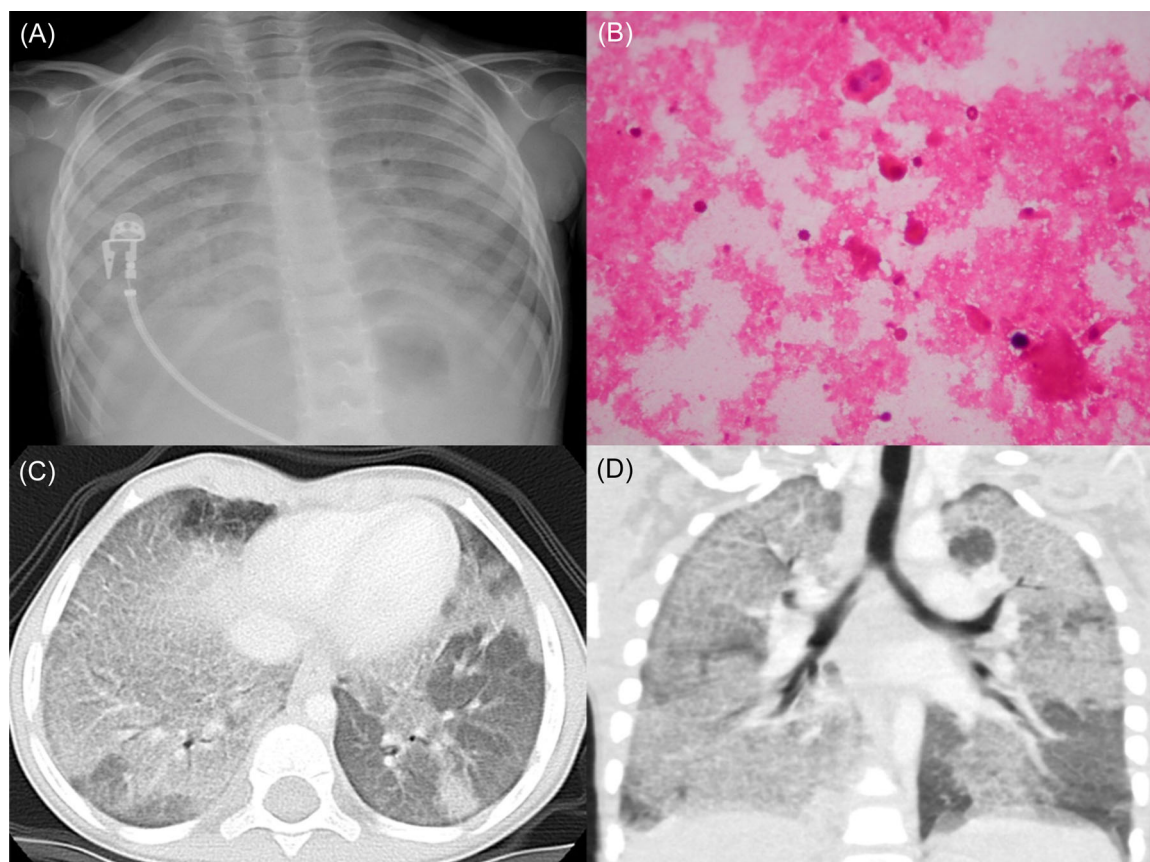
(A) PA chest X-ray demonstrates bilateral diffuse ground-glass opacities. (B) Amorphous eosinophilic hyaline material with macrophages in bronchoalveolar lavage fluid. (C) CT at the level of the lower lobes shows crazy-paving pattern, combining smooth interlobular septal thickening and ground-glass opacities. (D) Coronal reformatted CT image shows that the right lung has diffuse pattern of disease, whereas the left lung has somewhat geographic pattern with spared areas of upper and lower lobes. CT, computed tomography; PA, posterior anterior.
